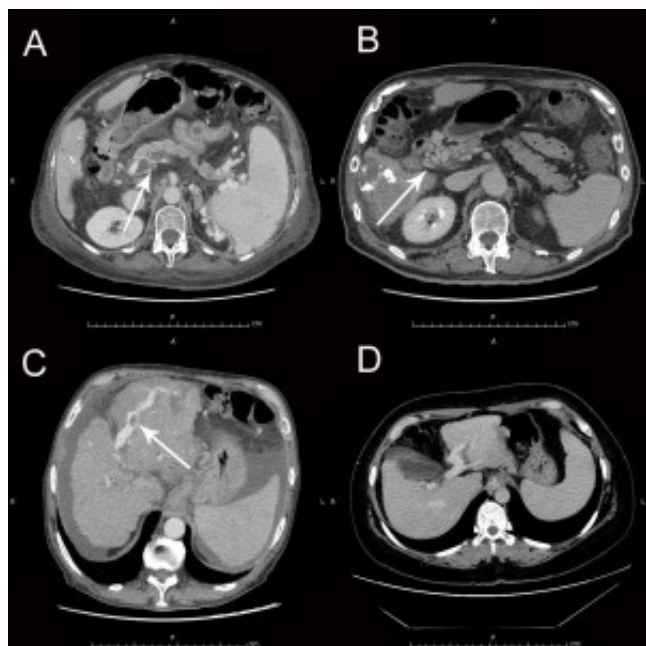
CT axial images in liver cirrhosis. A) Thrombosis of the portal vein extended to the distal splenic vein (arrow), with splenomegaly and peri-splenic collaterals. B) Portal cavernoma, with multiple large collaterals at the hepatic hilus (arrow), in a patient with hepatocarcinoma and previous lipiodol treatment. C) Thrombosis of the left branch of the portal vein, in its intra-parenchymal tract. D) Bent dilatation of the left main portal branch, with a scant intra-hepatic portal tree.
